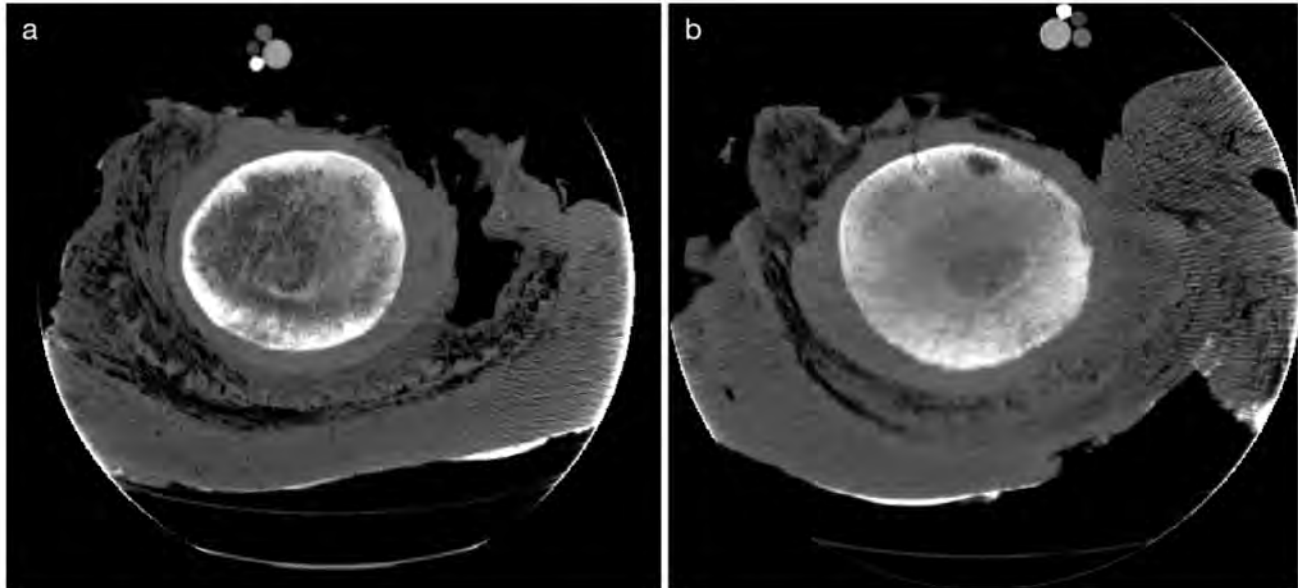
North Atlantic right whale (EgNEFL1103 / 3911; see Table 4); cause of death: confirmed chronic entanglement. Comparative CT images of right and left humeri at the same level. (a) Entangled flipper shows diminished opacity within the trabecular bone of the diaphysis compared to (b) the unaffected flipper. Image credits: Virginia Aquarium & Marine Science Center; CT scan interpretation courtesy of S. Dennison
